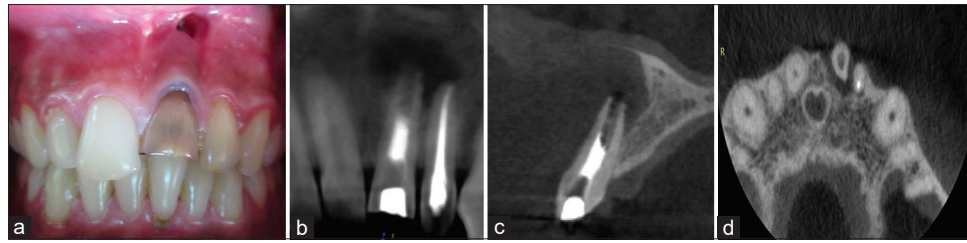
(a) Preoperative clinical photograph exhibiting discolored tooth #21 and associated defect. (b) Preoperative radiograph showing open apex, incomplete endodontic treatment, periapical lesion with the tooth #21, and acceptable endodontic treatment with tooth #22. (c and d) Cone-beam computed tomography scan revealing complete denudation of buccal cortical plate
